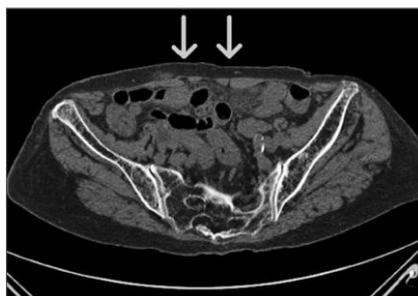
Previous CT. a narrow space among the bilateral rectus abdominis muscle was revealed 1 year before the CT.
